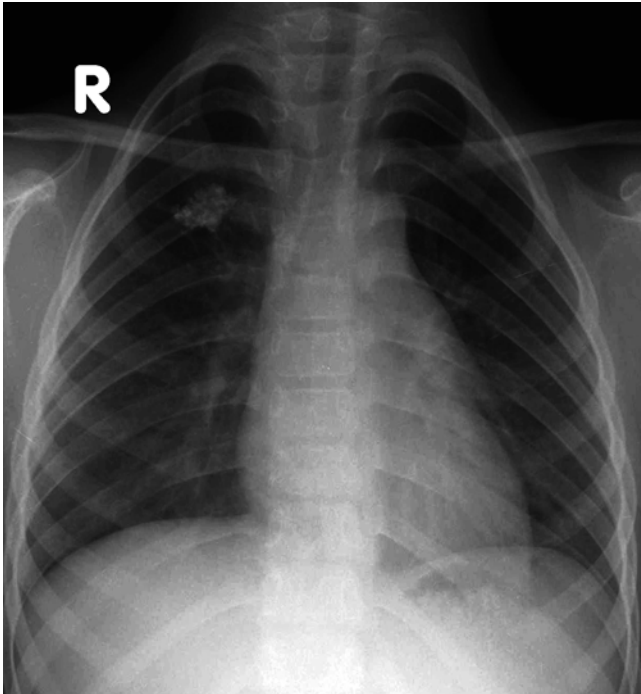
Primary TB infection. An asymptomatic 7-year-old boy had a chest x-ray as a school requirement, which reveals a calcified granuloma on the right upper lobe. This corresponds to a calcified Ghon focus, a sign of TB infection
